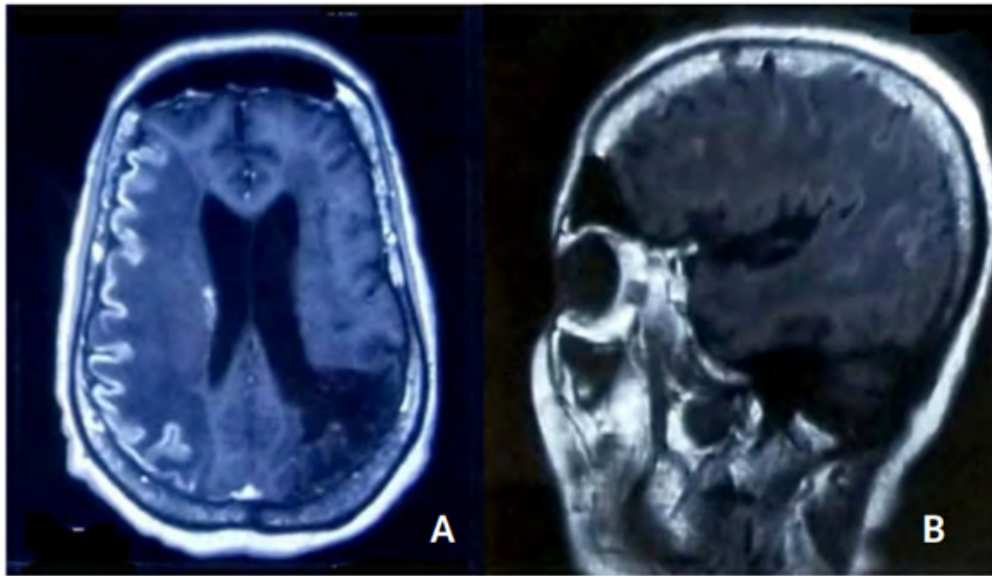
Brain MRI in T1-weighted spin echo sequence in sagittal section without injection of contrast product (A) showing areas of diffuse subcortical hypo-signals with a curvilinear right fronto-parieto-temporal cortical hyper-signal, in axial section with injection of the contrast material (B) showing right fronto-parieto-temporal gyriform contrast enhancement.
